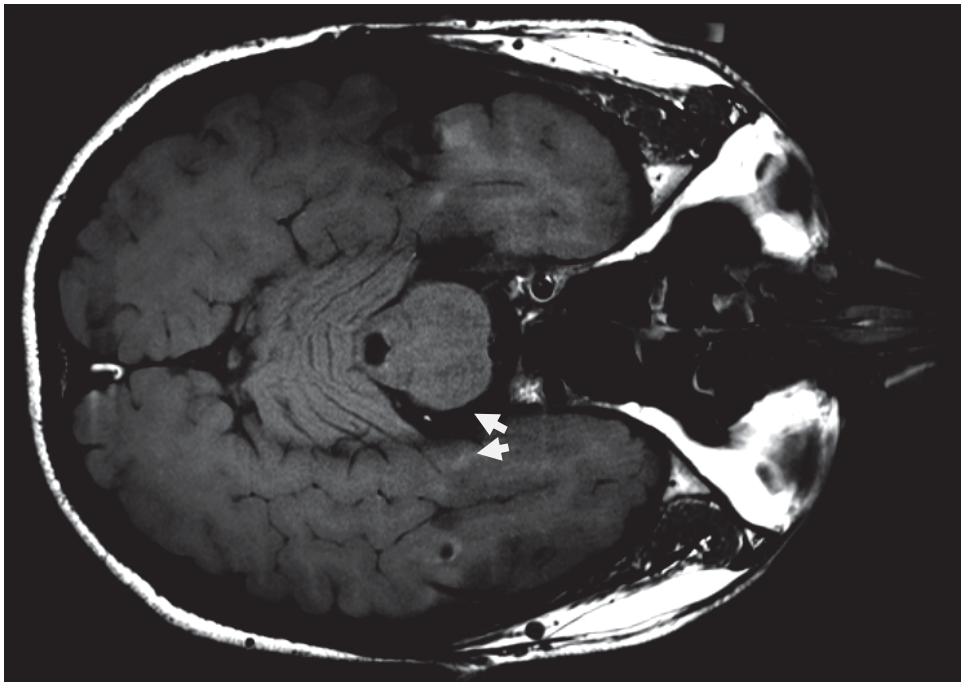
My loci coerulei (white arrows). Neuromelanin-sensitive MRI scanning sequence described by Sasaki et al. (2006) and Shibata et al. (2008).
